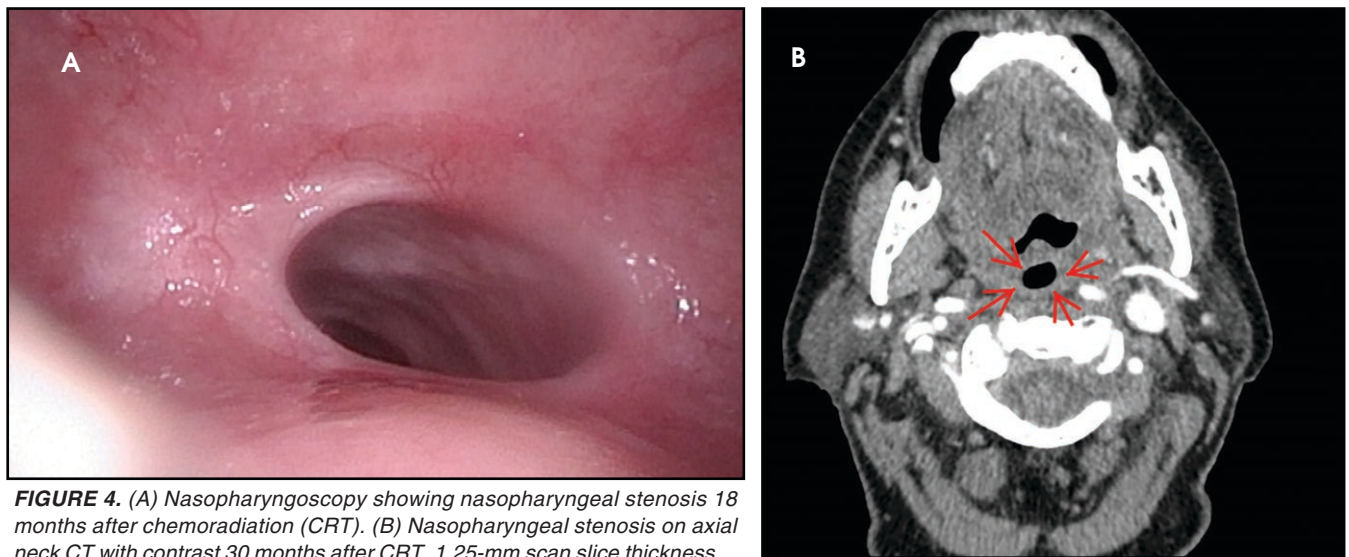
(A) Nasopharyngoscopy showing nasopharyngeal stenosis 18 months after chemoradiation (CRT). (B) Nasopharyngeal stenosis on axial neck CT with contrast 30 months after CRT, 1.25-mm scan slice thickness.
